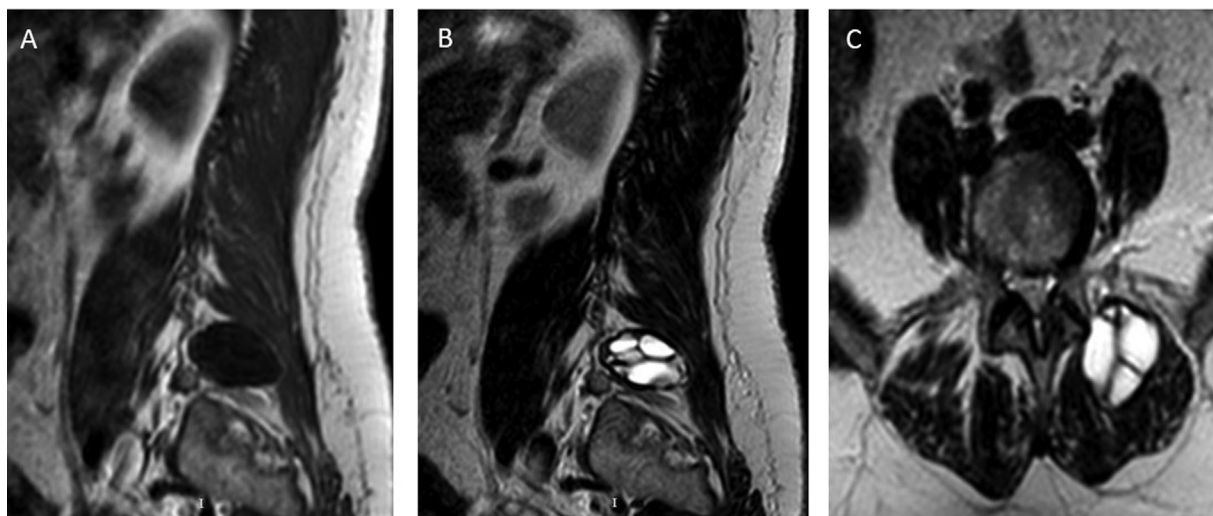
Preoperative magnetic resonance (MR) imaging of the patient. (A) Sagittal T1-weighted images showing cystic lesion in paravertebral muscles at level L5. (B) Sagittal T2-weighted image showing cystic lesion with high signal intensity. (C) Axial T2-weighted image of the cystic lesion in the left paravertebral muscle.
